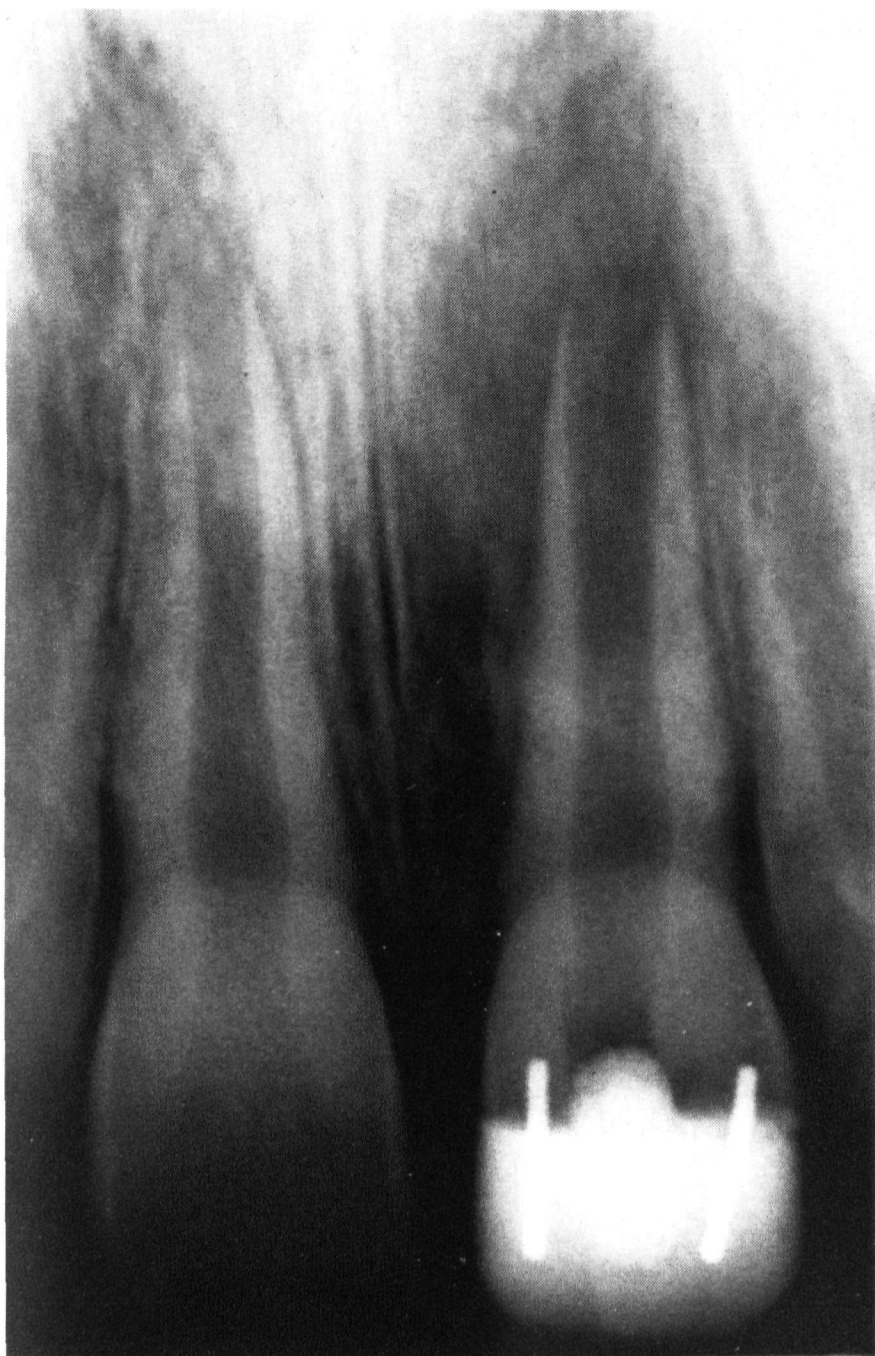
Representative anterior tooth (#9) with an open apex and associated periapical radiolucency.
